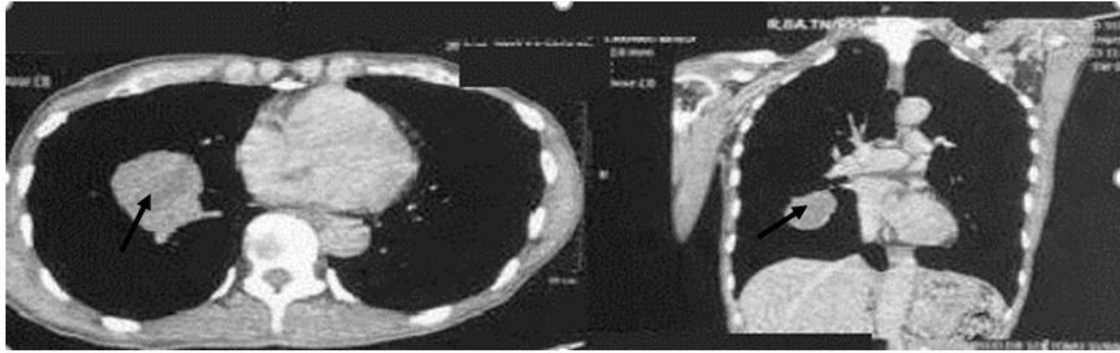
Contrast-enhanced CT scan revealing a mass in the anterobasal segment of the right lung's inferior lobe (black arrow).
